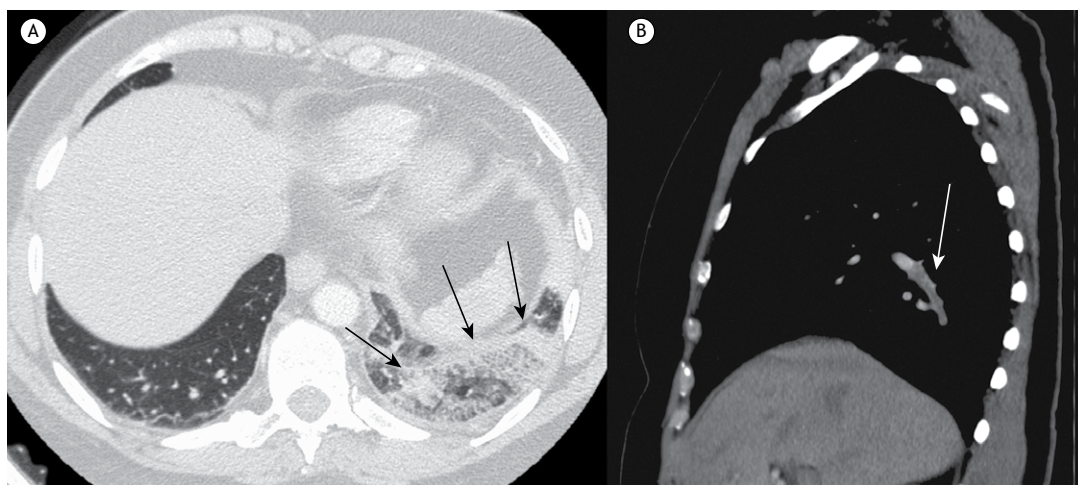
In A, computed tomography angiography image, with lung window settings, showing oval lesions characteristic of pulmonary infarction with the reversed halo sign (black arrows) in the subpleural region of the left lower lobe, comprising heterogeneous areas of low attenuation. In B, sagittal reconstruction, with mediastinal window settings, showing an extensive filling defect (white arrow) in the segmental branch that connects the left pulmonary artery to the posterior basal segment of the lower lobe.
